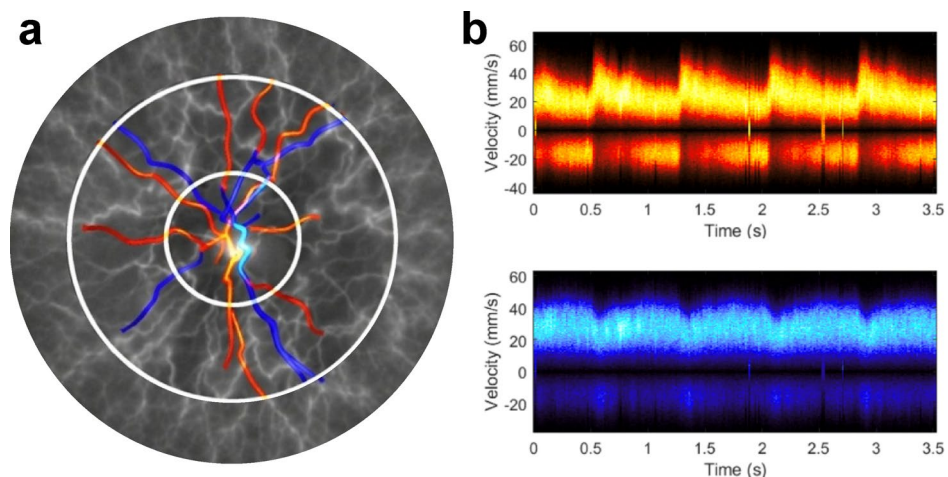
Representative laser Doppler holography (LDH) output. (a) LDH image showing the optic nerve head with segmented retinal vessels (arteries in orange, veins in blue). To protect biometric privacy, the vascular architecture has been synthetically modified using AI. (b) Velocity spectrograms (mm/s) over the 3.5-second acquisition in the arteries (top, orange) and veins (bottom, blue), showing pulsatile waveform morphology.
